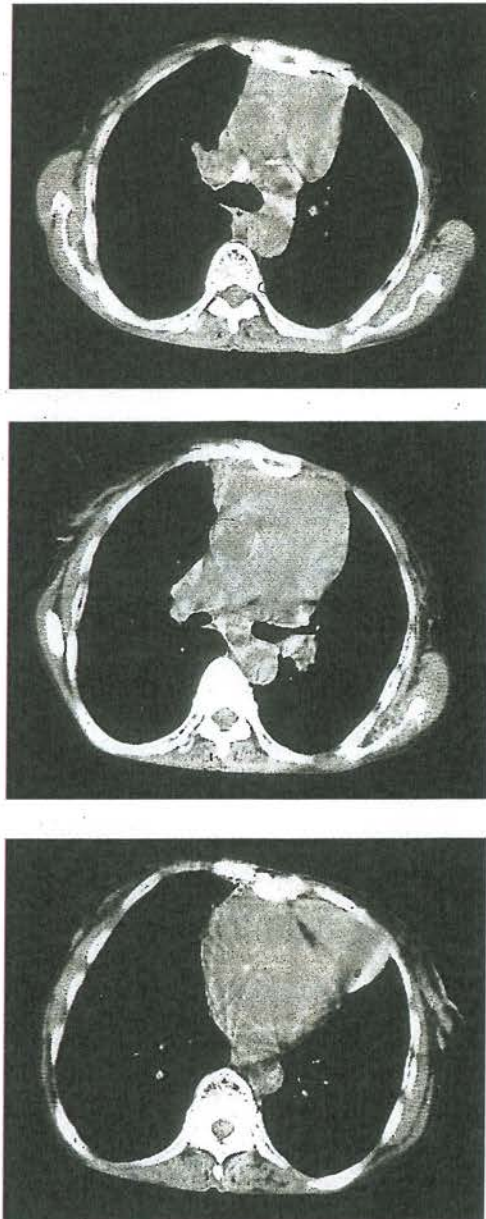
CT scan of the mediastinum showing a thymoma
